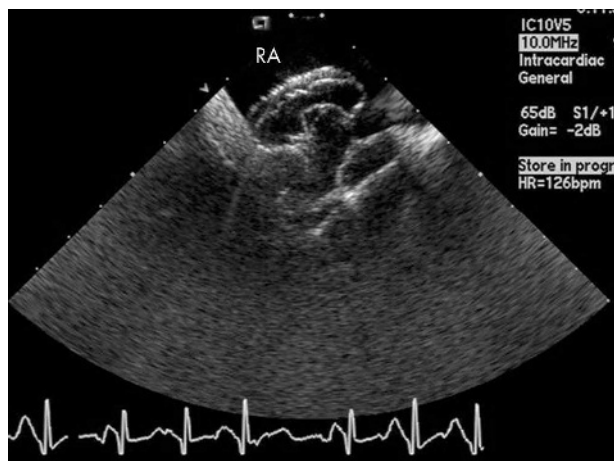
Intracardiac echocardiogram of a patient with an ostium secundum ASD just after apposition of an Amplatzer septal occluder umbrella device. The intravascular echocardiographic probe is located in the right atrium. Both sides of the umbrella and its main axis traversing the ASD are clearly visualised. RA, right atrium.
